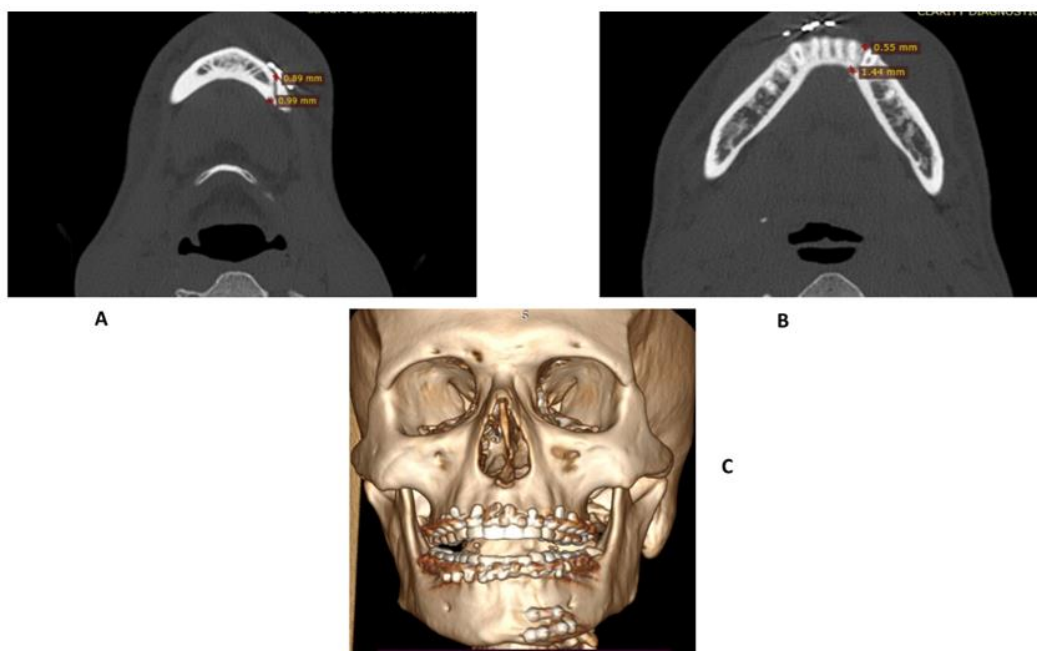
Postoperative CT scan of the patient revealing reduced interfragmentary gap between fractured segments and continuity in the (a)inferior border of the mandible (b) at alveolar bone level (c) and in 3D reconstruction
